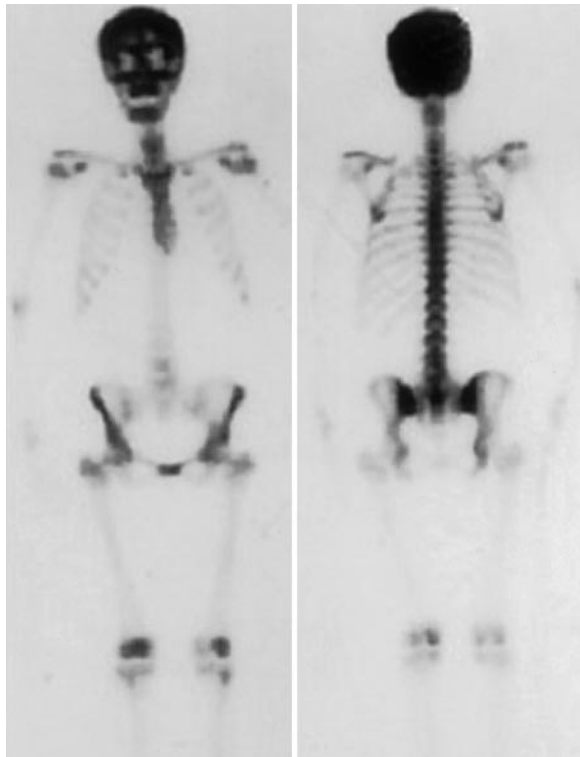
Anterior (left) and posterior (right) whole-body scintigrams obtained in a patient who fell demonstrate multiple foci of increased radiotracer uptake. The linearly distributed rib foci and H-shaped sacral activity indicate trauma as the cause of these foci. The increased activity in the right proximal humerus is due to a fracture.
